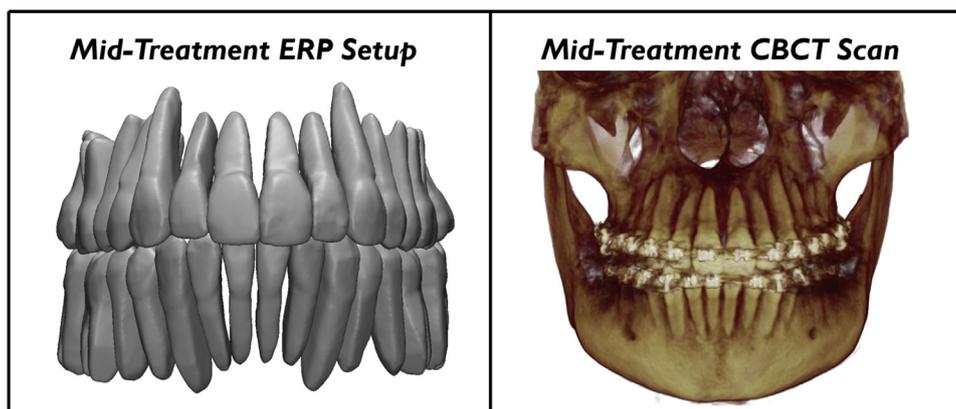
Examiners evaluated the root position for both the ERP setup (*left*) and its corresponding mid-treatment CBCT scan (*right*).
